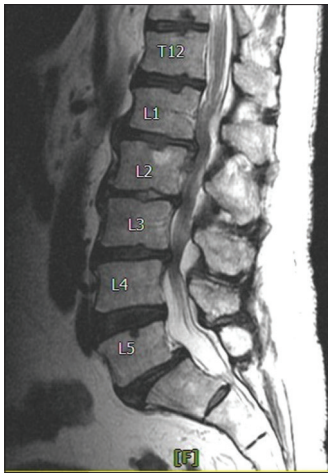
Magnetic resonance imaging of the lumbosacral spine with intravenous contrast showing epidural crescent collection posteriorly L1–2 consistent with epidural abscess, enhancement of the vertebral bodies L3–4, and multiple fluid collections extending in the paraspinal musculature from L2 to S1
